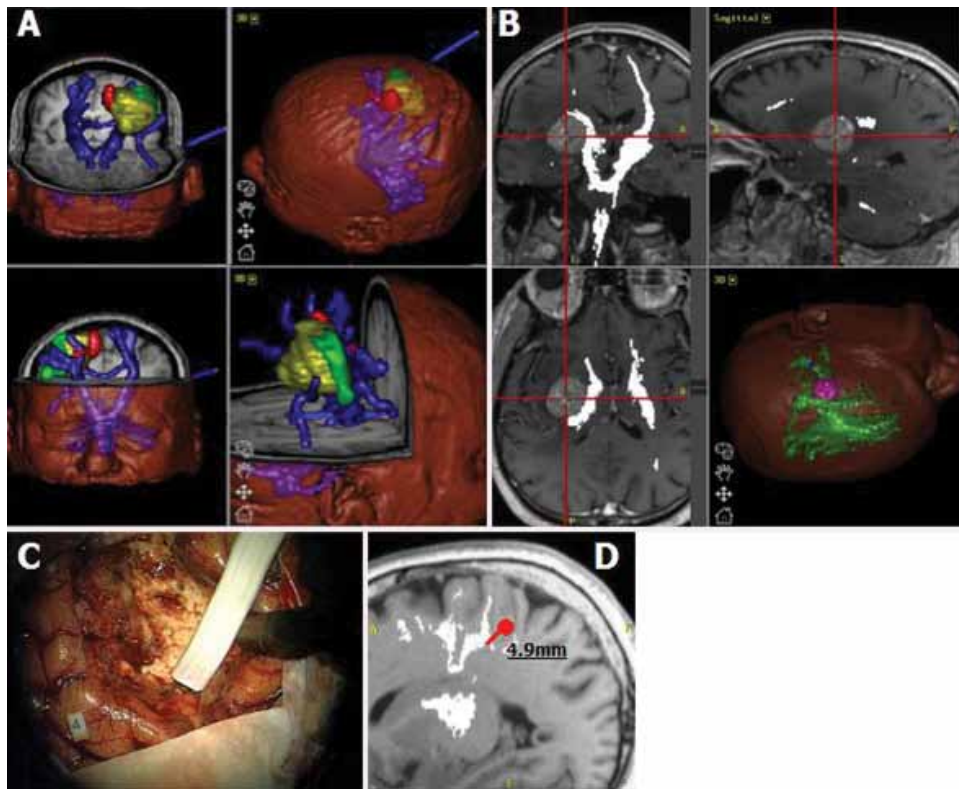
Intraoperative multimodal subcortical navigation. A: A 3D display of tumor (yellow), hand (green), and foot (red) motor fMR imaging activity and pyramidal tracts (blue) superimposed on a T1 MR imaging anatomical study. B: Pyramidal tracts superimposed on a Gd-enhanced T1-weighted MR imaging study in a patient with a deep-seated metastasis. C: Intraoperative photograph showing an sCS after microsurgical resection of a cortico-subcortical tumor. D: Real-time navigation of a point subjected to sCS with positive motor response (red dot and line), and the measurement of the distance to the nearest corticospinal tract.
